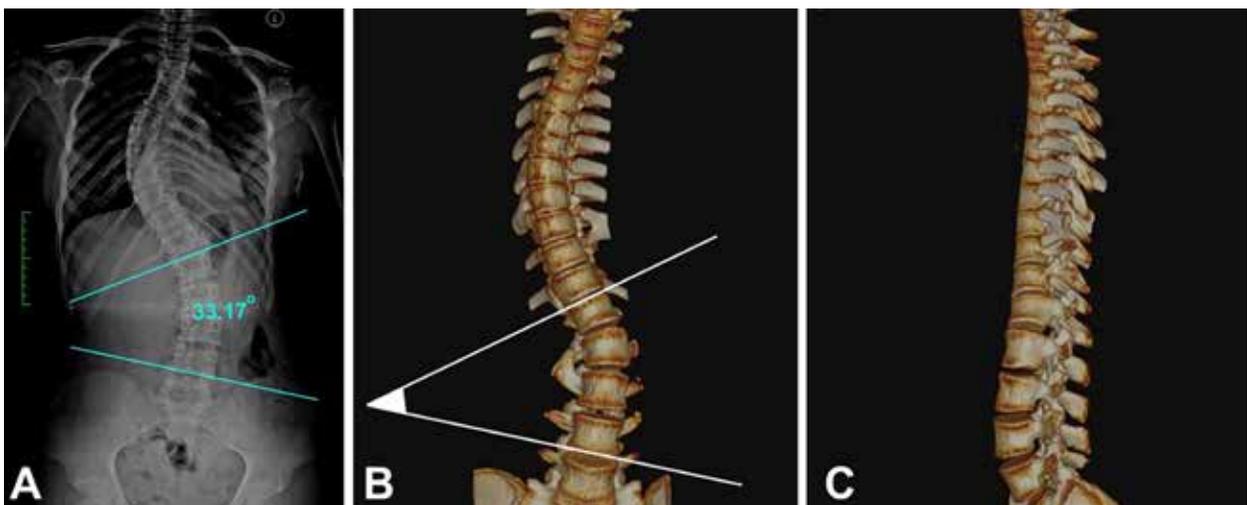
(A) Computer-assisted Cobb angle measurement on anteroposterior radiographs using OsiriX software; (B) 3D analysis and Cobb angle measurement from 3D reconstructed CT image; (C) 3D reconstructed image of the spine in the sagittal plane.
